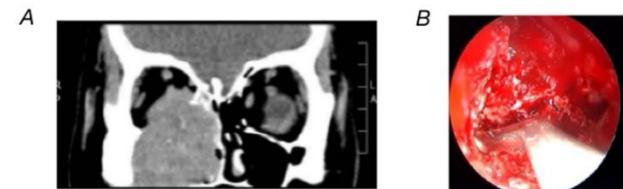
(A) Coronal CT; sinuses showed the aggressive, destructive lesion to the inferior orbital rim reaching the optic nerve and (B) post-endoscopic debridement of the granulomatous fungal infection.
